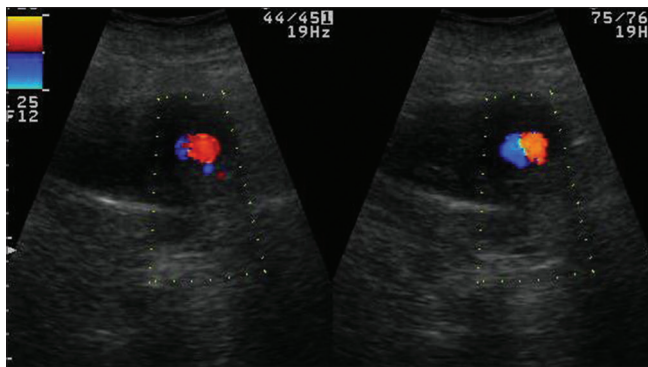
Color Doppler image shows well-defined pseudoaneurysm in left lateral wall of uterus with dual color
